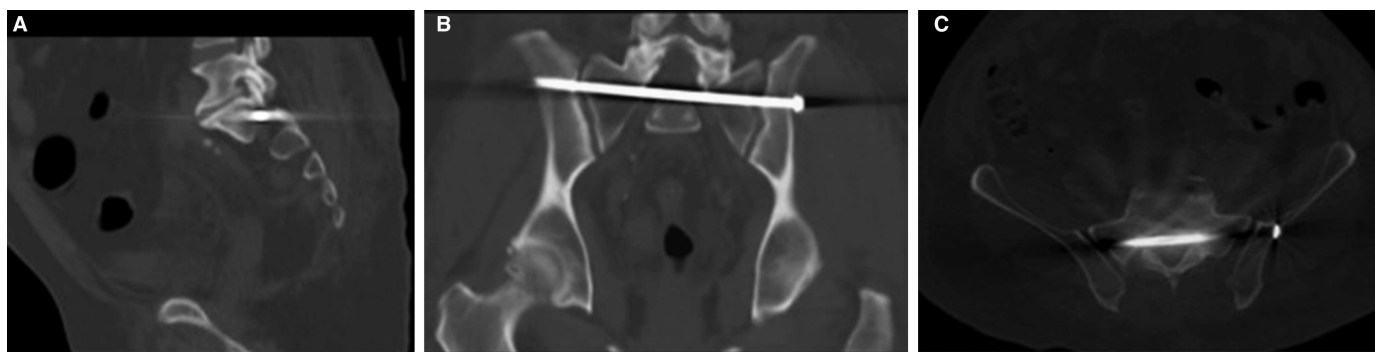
A–C, Computed tomographic cuts demonstrating sacroiliac screw fixation adjacent to the left S1 foramen and anterior thecal sac after initial procedure. The postoperative numbness in the left S1 distribution may represent the direct neural trauma or irritation that ultimately initiated the Guillain-Barré syndrome cascade.
